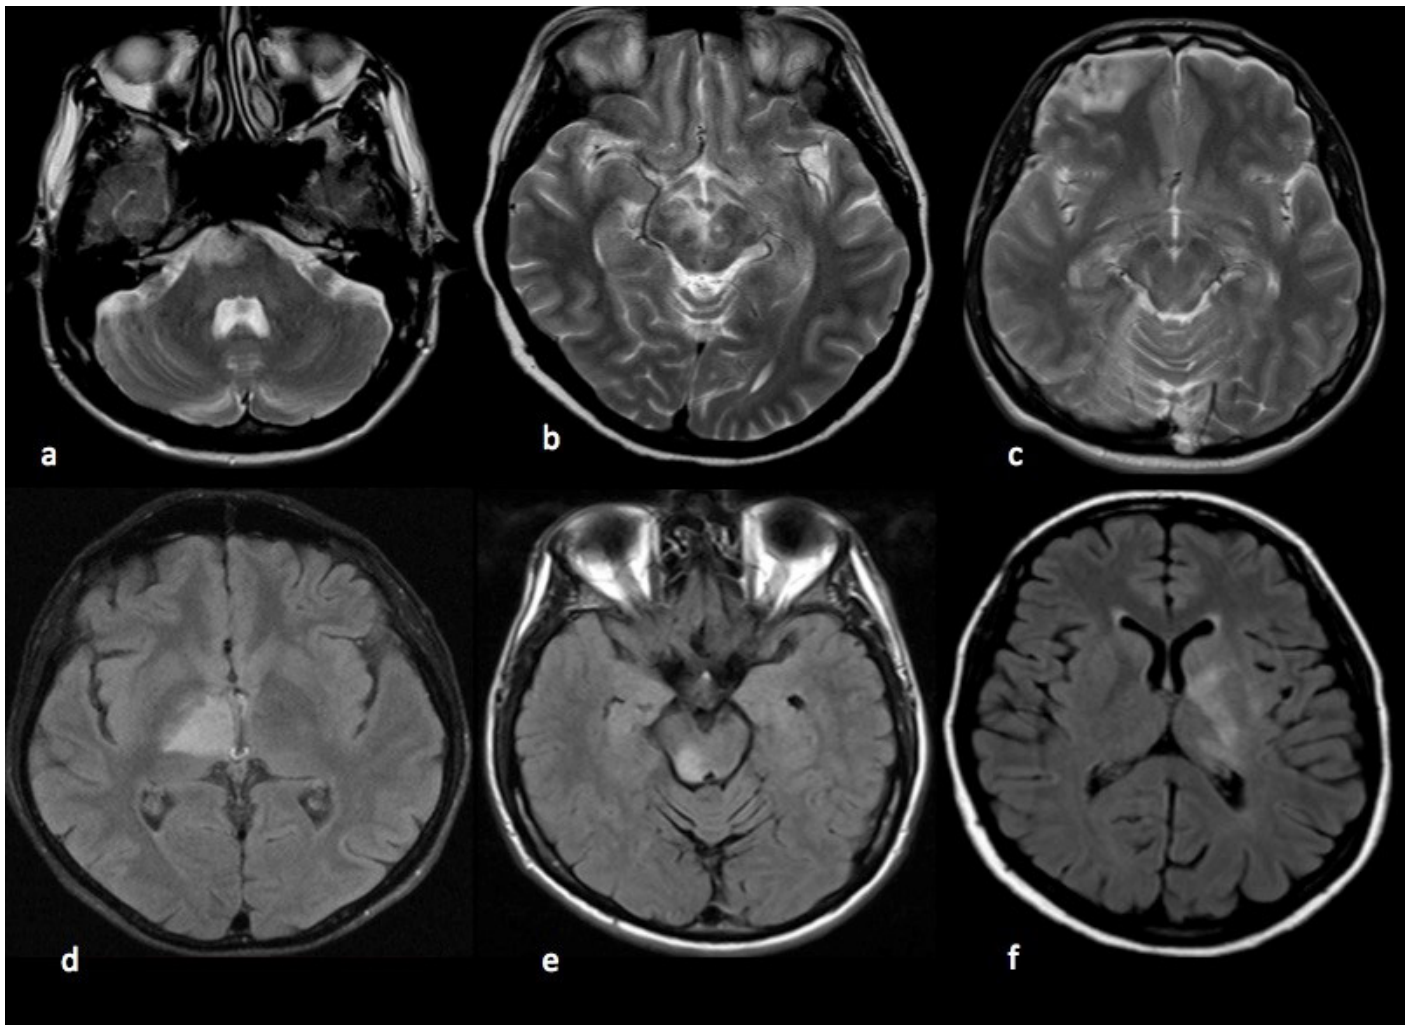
Parenchymal NBD lesions of six different patients during the acute attack. T2 lesions in anterior pons (a), right anteromedial mesencephalon (b), and right anterior frontal lobe (c). T2 FLAIR lesions in right thalamus (d), right posterolateral mesencephalon, (e) and left thalamus including capsula interna (f)
